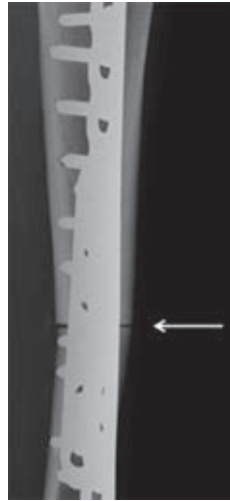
Anteroposterior X-ray of a proximal femoral allograft. There is  $\geq 50\%$  cortical contact at the proximal osteotomy (white arrow): grade 2A.
